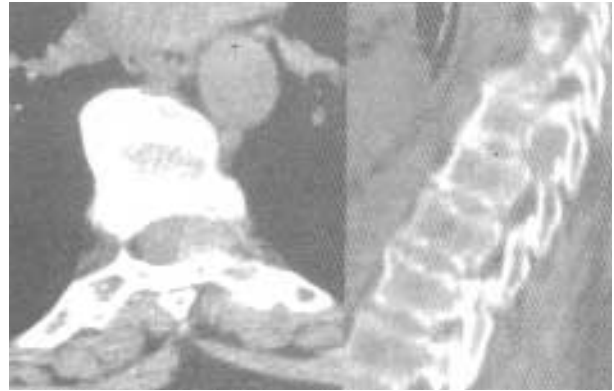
Left: The lesion had been enhanced after contrast injection at thoracic CT. Right The lesion dilated the left neural foramen at the T8 level.
